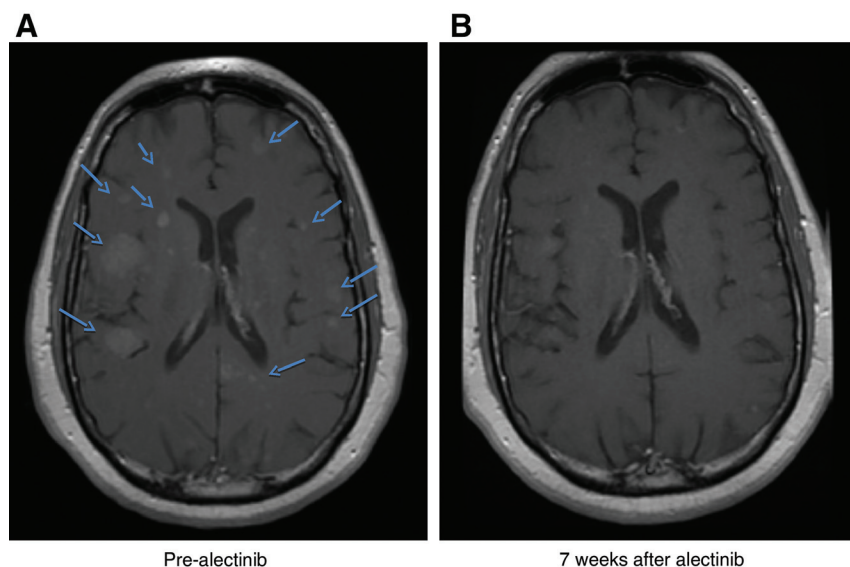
Marked regression in brain parenchymal metastases in a 46-year-old, ALK-positive lung cancer patient treated with alectinib. This patient had previously received both crizotinib and ceritinib, relapsing in the central nervous system after each agent. Axial, T1 post-gadolinium magnetic resonance images A) before alectinib and B) on alectinib.
